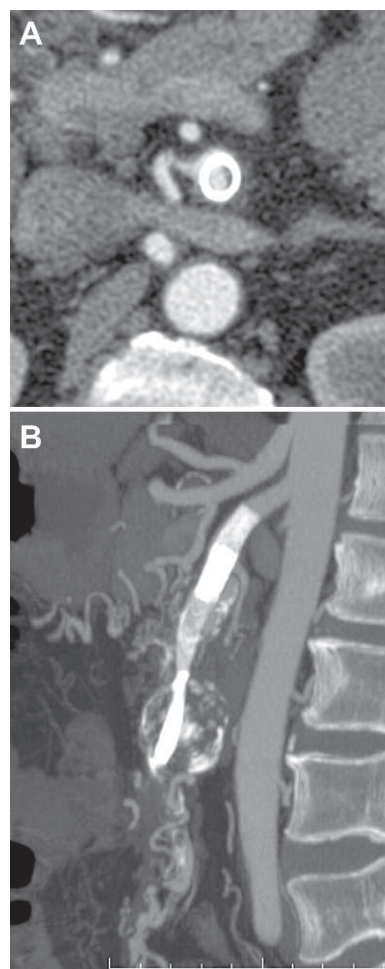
♦ (A) An axial CT scan and (B) MIP reconstruction show partial obstruction of a CMFM deployed in a SMA aneurysm; the stent remained patent in front of the takeoff of 2 collateral branches, one going retrograde to the hepatic artery, which was occluded at its origin, and the other supporting the bowel's vascular bed.
